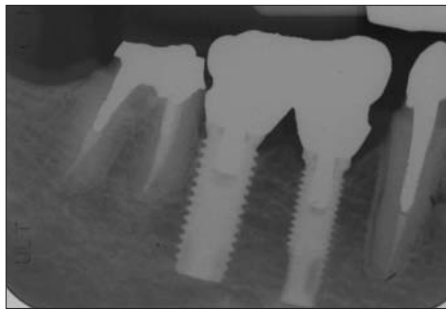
Periapical radiograph revealing that tooth No. 29 was removed and implants were placed in tooth No. 29 and No. 28 position while teeth No. 27 and No. 30 were endodontically retreated with placement of new post and cores.
